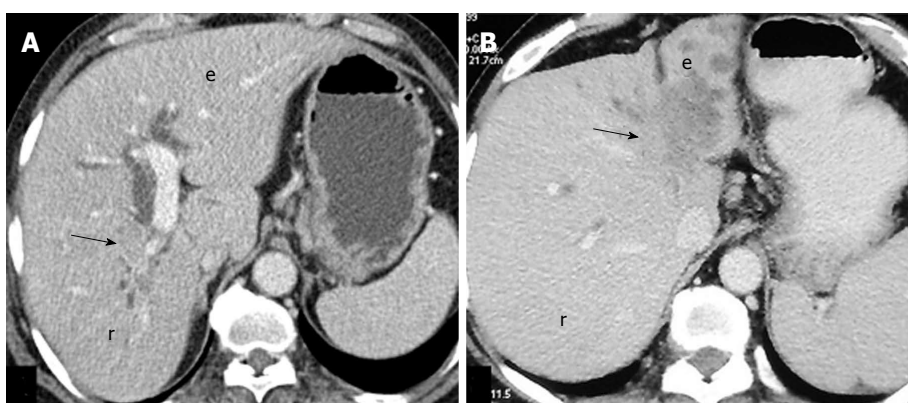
Axial computed tomography images showing atrophy of right lobe (r) due to hilar mass (arrow) in A, and atrophy of left lobe (l) caused by a mass (arrow) in B.
